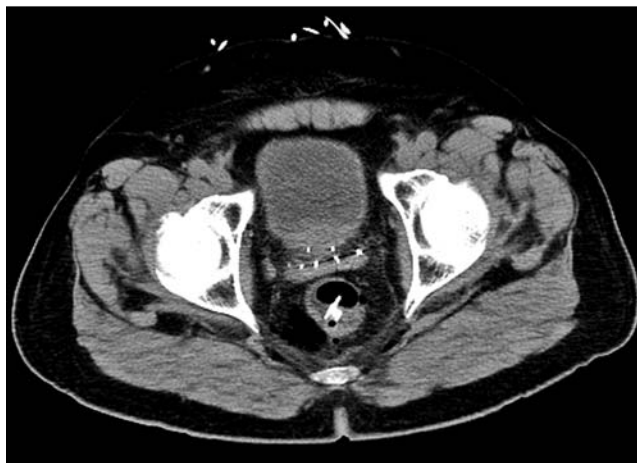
CT scan on day 3 showing successful closure of the rectal defect with endoclips, with a decrease in retroperitoneal free air.
